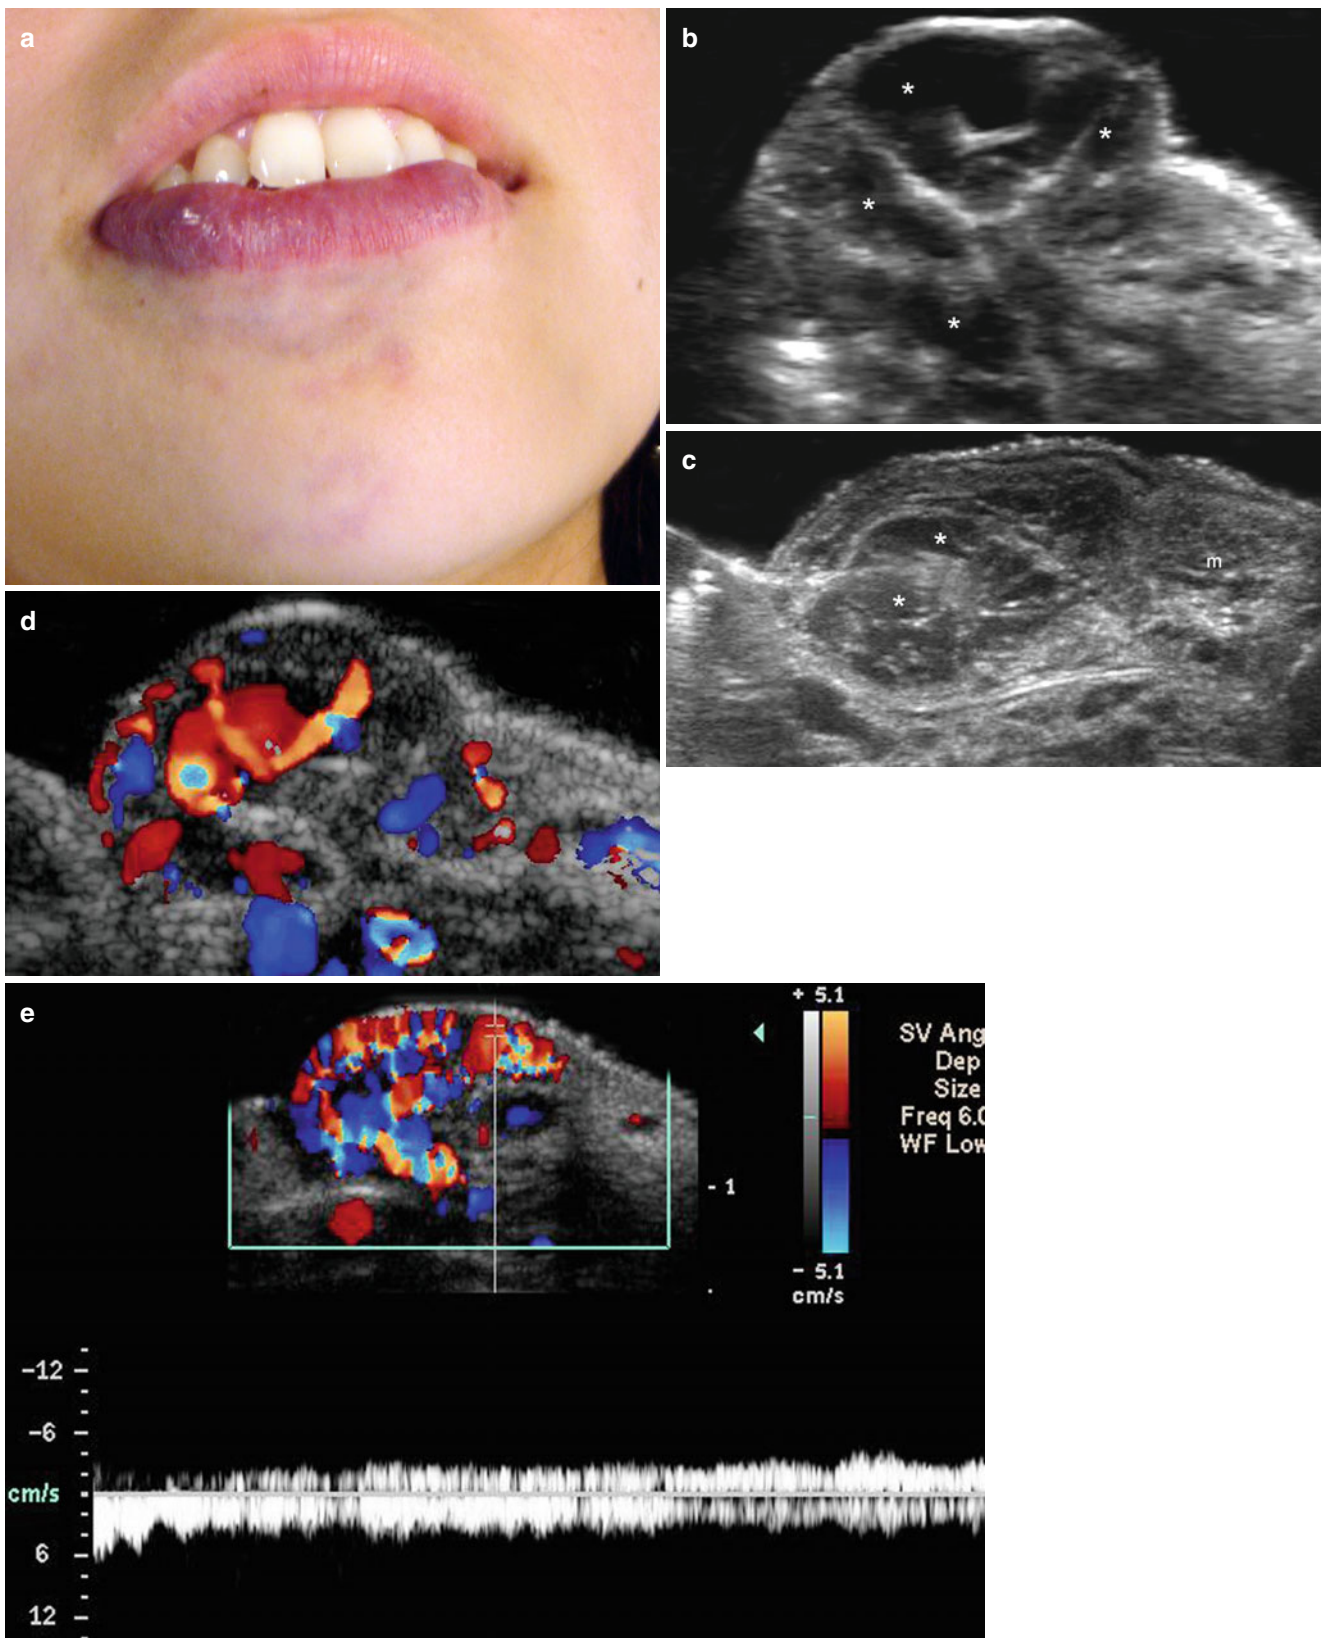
(a–e) Low-flow venous vascular malformation. (a) Clinical erythematous lesion in the right border of the lower lip. (b) Grey scale ultrasound image (longitudinal view) and (c) (transverse extended view) show multiple anechoic tubules and pseudocystic
